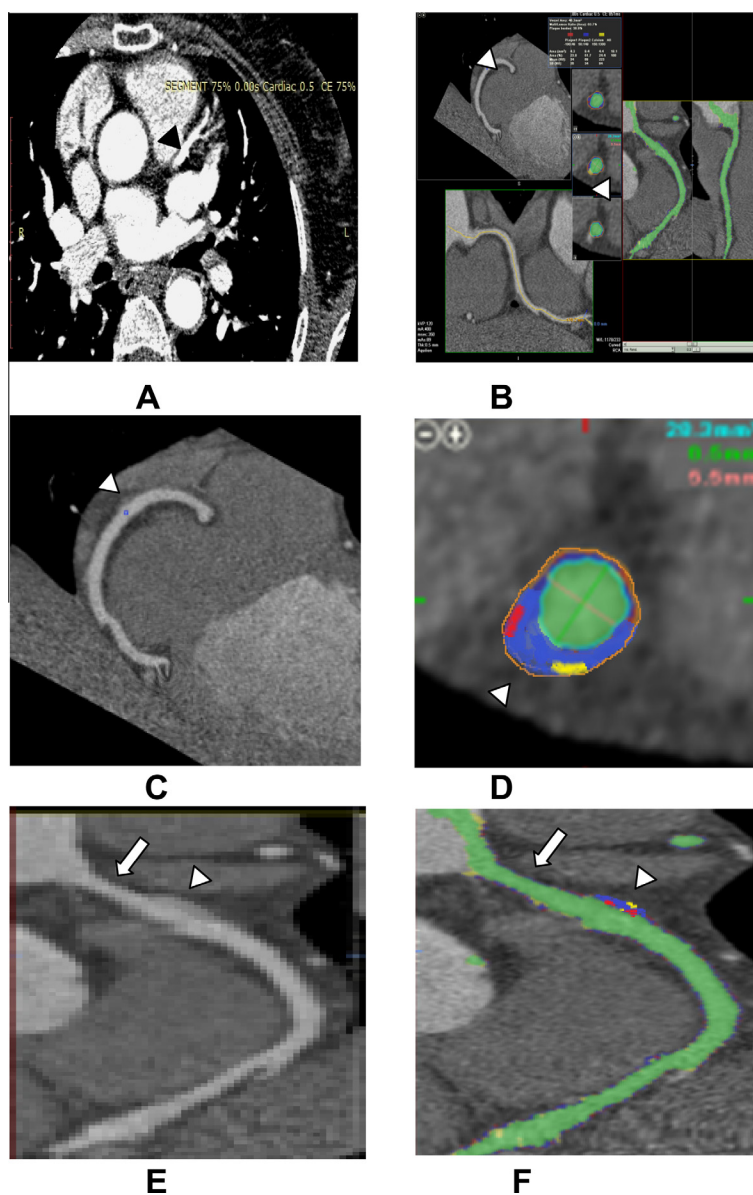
A male patient, 40 years old, with history of controlled hypertension, came for check up examination with no cardiac symptoms. (A) Contrast-enhanced 64 multi-detector row cross sectional CT image: average caliber of LAD is seen arising from LM demonstrating an eccentric mixed plaque, predominantly of soft tissue component at its mid portion causing no significant stenosis. The plaque measures 5.7 mm in length and 1.4 mm in width (black arrowhead). (B) Curved multiplanar reformation images of left anterior descending artery (LAD) show a single eccentric predominantly soft tissue plaque having foci of calcification causing positive remodeling (as shown by white arrowhead). Note the lumen is patent with no plaque encroachment upon the lumen. (C) Magnified MPR image shows the +ve remodeling as shown by white arrowhead. (D) A colored cross-sectional image at site of positive remodeling (white arrowhead) showing the medium attenuation plaque (blue colored), and foci of calcium (yellow colored) and scanty lipid (red colored). (E&F) colored and grey scaled magnified MPR showing the same findings. Note the reference segment is free of plaques (white arrow). The calculated remodeling index = 1.22.
